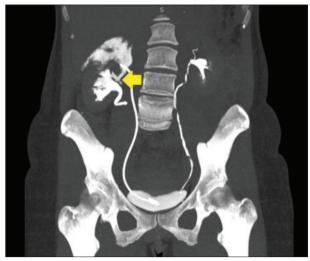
Preoperative CT scan: spontaneous rupture of the pelvis (arrow) and an outflow of intravenous contrast around the upper pole of the right kidney
